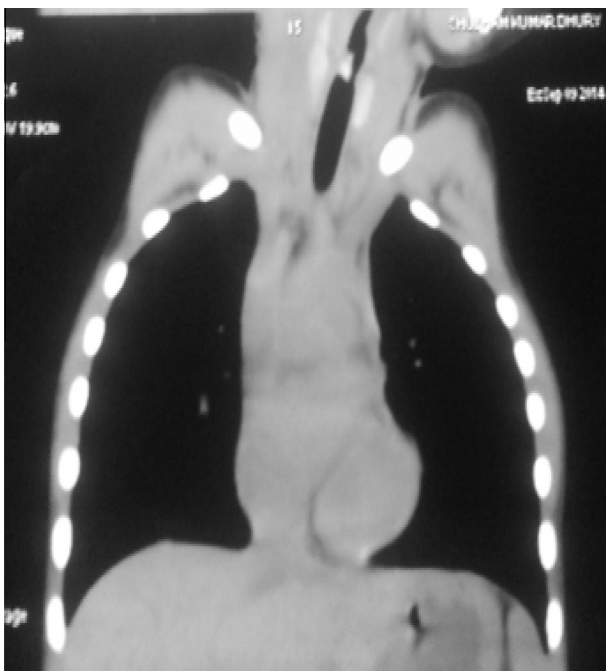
CT scan of the neck and chest (coronal view) showing FB in upper third of the trachea.
